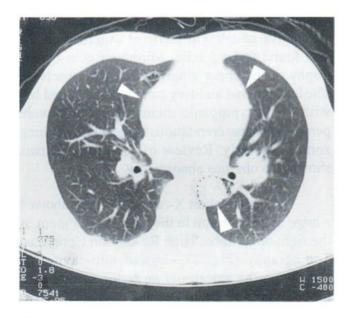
Nodules seen at both hilar region on high resolution computer Tomography (HRCT)
